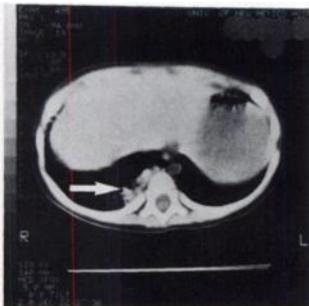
CT scan of Patient 1 showing lesion in right lower lung field (arrow).
